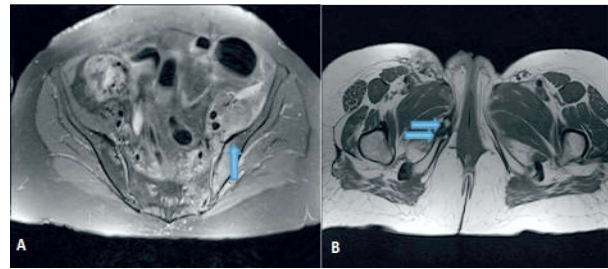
MRI showing fatty marrow, diffuse hyperintense signals in sacral ala and left iliac bone with widening of left sacro-iliac joint and muscle changes
